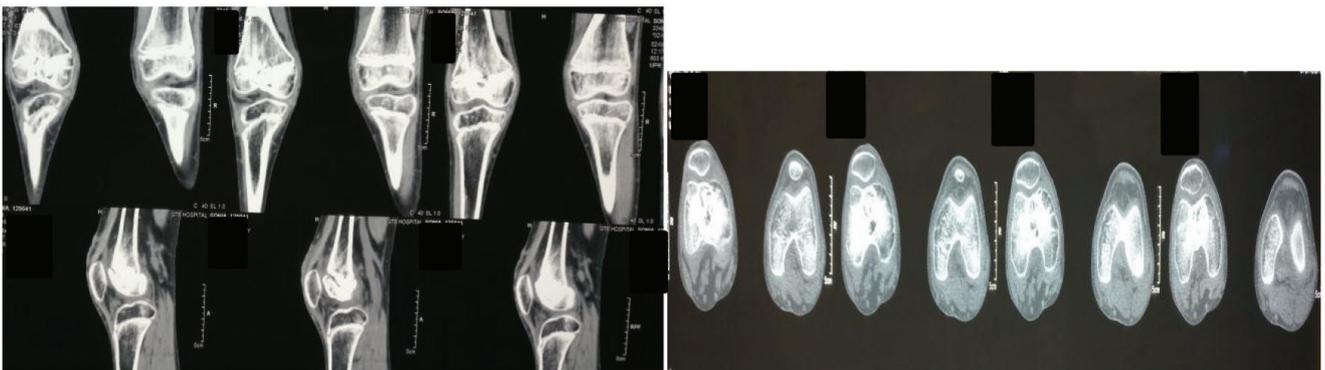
CT scans sections showing graft incorporation at 17 months post op.
